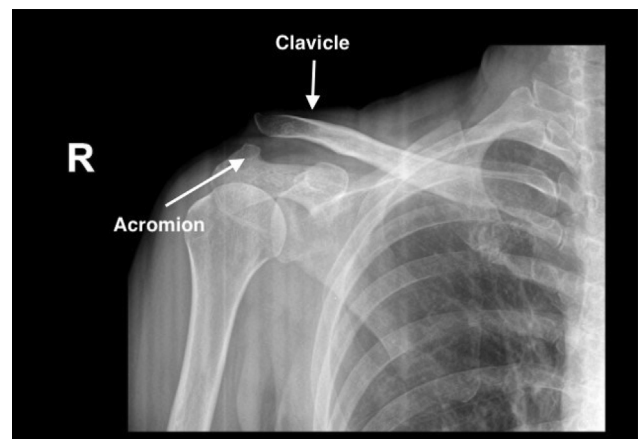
Preoperative radiograph (anteroposterior view) of the right shoulder, which confirms a type V acromioclavicular joint separation.
